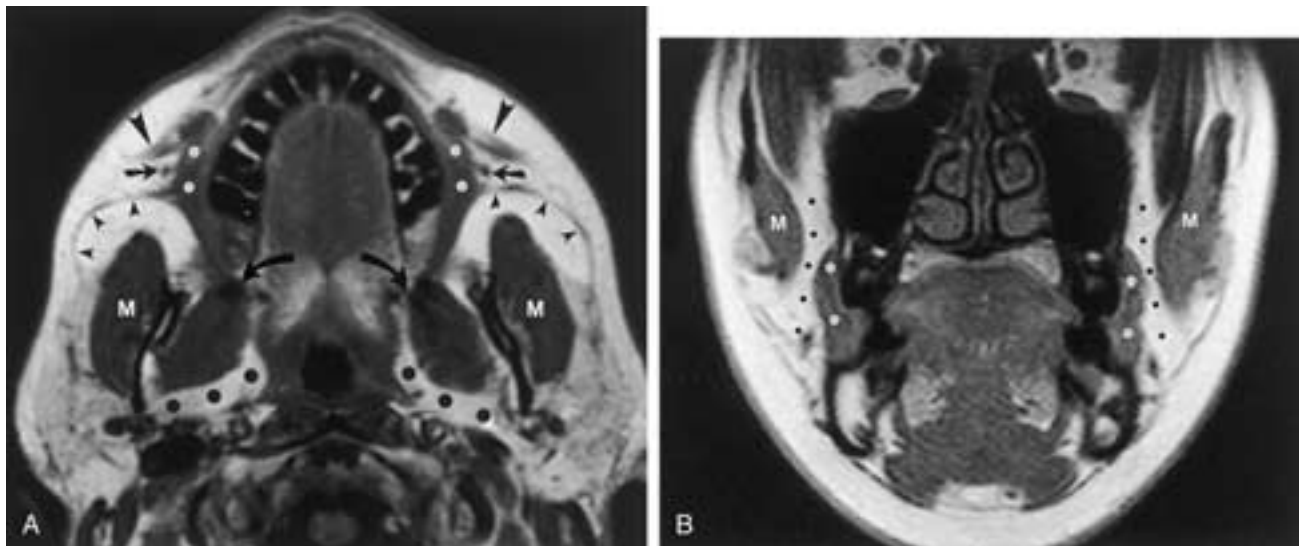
Buccomasseteric region, normal anatomy. (A) Axial and (B) coronal T1-weighted MR images demonstrate the anatomy of the buccal spaces. These fat-filled spaces lie posterior to the zygomaticus major muscles (*large arrowheads*), anterior and medial to the masseter muscles (*M*), and lateral to the buccinator muscles (*white dots*). The parotid gland ducts are well visualized on the axial image (*small arrowheads*) as they cross the buccal fat pads to pierce the buccinator muscles and open into the vestibule of the mouth opposite the second maxillary molars. The facial veins (*straight arrows* in A) are visualized anterior to the parotid ducts, posterior to the zygomaticus major muscles, and lateral to the buccinator muscles. The parapharyngeal space fat (*large black dots* in A) is also well seen, medial to the mandible and medial pterygoid muscles and lateral to the pharyngeal constrictor muscles. The region of the pterygomandibular raphe is indicated by the curved arrows in A. The buccal space fat is indicated by the small black dots in B.
